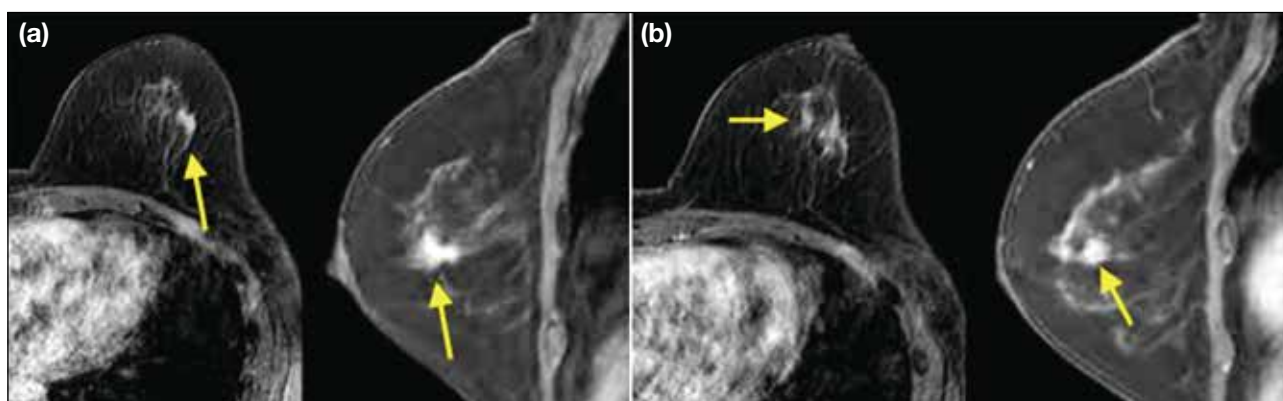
One of the false-positive cases in which the suspected multicentric lesions were found to be atypical apocrine adenosis on final pathology following mastectomy. (a) Post-contrast T1-weighted images: axial (left) and sagittal (right) views show the primary tumour (intermediate-grade ductal carcinoma in situ [DCIS]) as focal clumped non-mass enhancement (NME) [arrows]. (b) Post-contrast T1-weighted images: axial (left) and sagittal (right) views of the multicentric foci show focal nodular NME at L10H, mid-depth of the breast (i.e., near the back of the left breast at the 10 o'clock position) [arrows]. The imaging features of DCIS and atypical apocrine adenosis on magnetic resonance imaging are similar, making them difficult to distinguish. Common benign NME lesions include fibrocystic change, apocrine metaplasia, pseudoangiomatous stromal hyperplasia, and post-irradiation changes.
